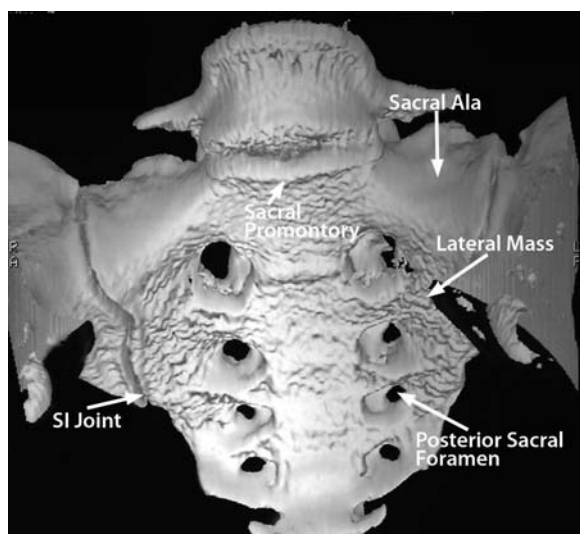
Three-dimensional CT reformation demonstrating an anterior view of the sacral anatomy
